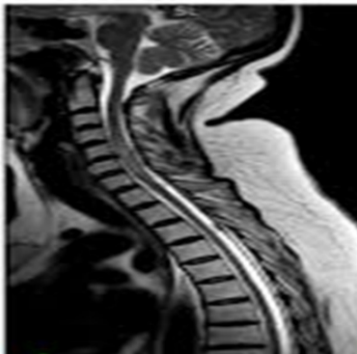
Sagittal slice of MRI cervical spine shows disc degenerative changes with reduced signal intensity T2
